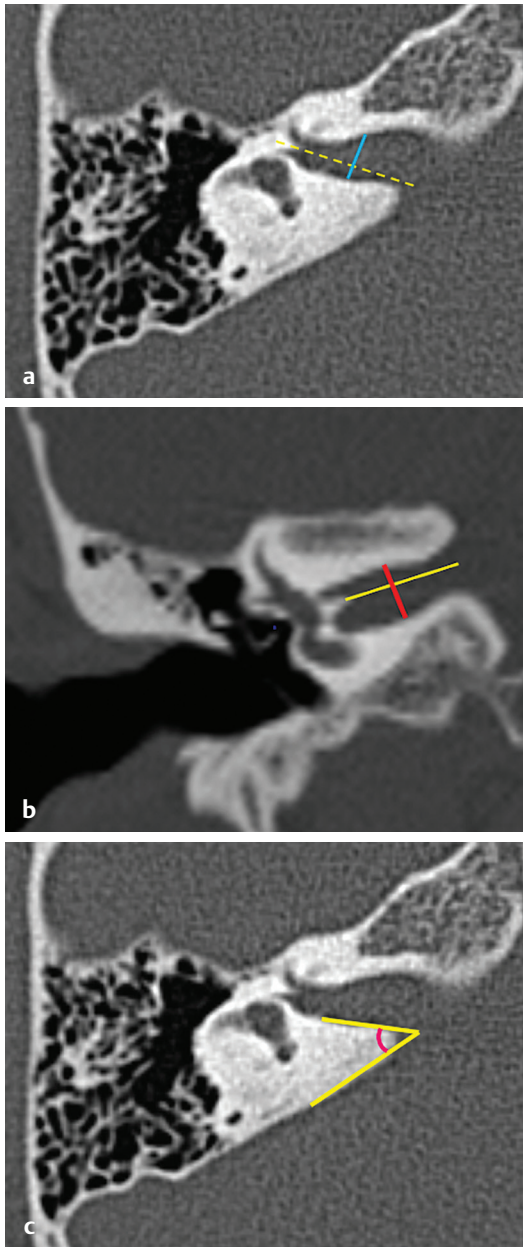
HRCT temporal bone, bone window, (a) axial section shows measurement of the width of the internal acoustic canal (IAC) at its midpoint (yellow dotted line, long axis of IAC), (b) coronal section showing the measurement of the height of IAC, (c) axial section shows measurement of the angle of orientation of IAC.
